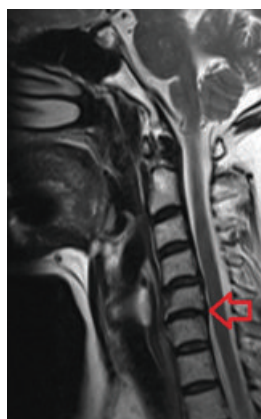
MRI single slices of a 58 years old female with C5/C6 bulged disk.
